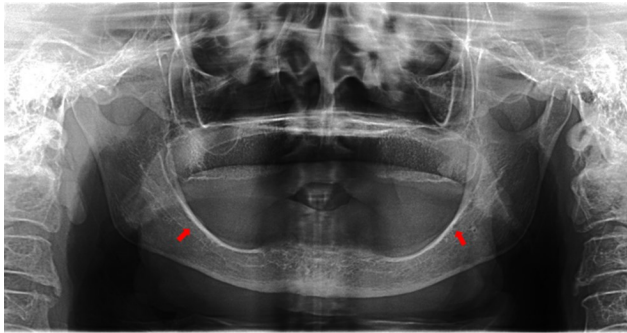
Panoramic radiograph showing severe alveolar ridge resorption where the mandibular canal and/or mental foramen (red arrow) are above the crest of the alveolar ridge or with partially resorbed on one or both sides.
